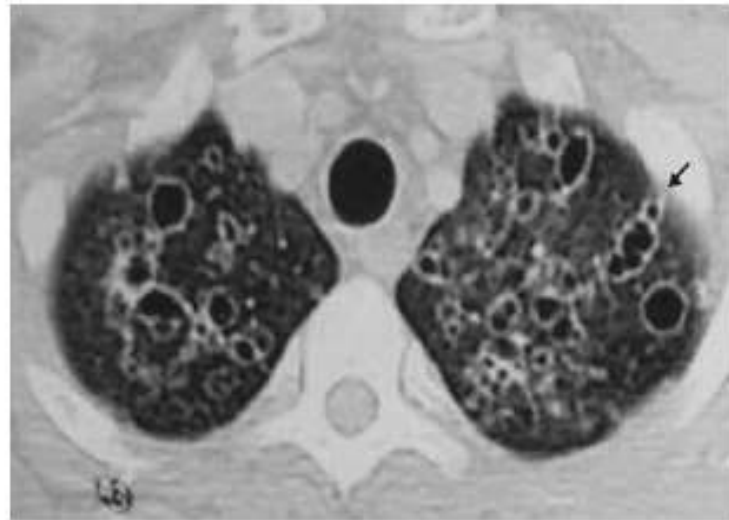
Progressing cystic PJP on HRCT: cysts become confluent and extend to the periphery (arrow).
